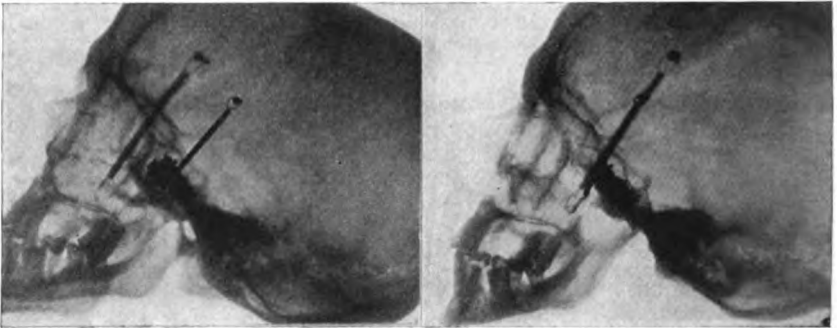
Stereoscopic radiograph of the sphenoidal sinus filled with lead shot.
